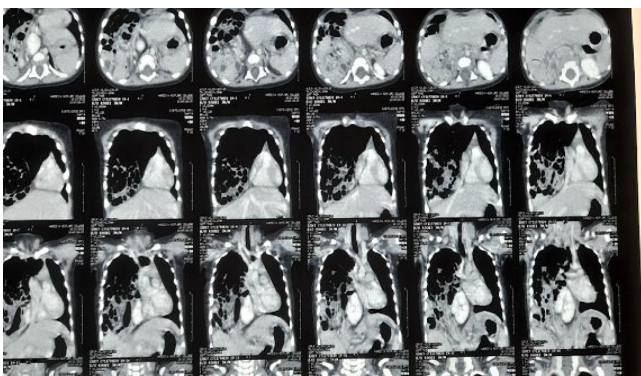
CT of chest and abdomen showing bowel loops within right side of chest, left normal positioned kidney, empty right kidney fossa area, and right ectopic intrathoracic kidney in 10 months-old-boy diagnosed right-sided CDH (case 4).
